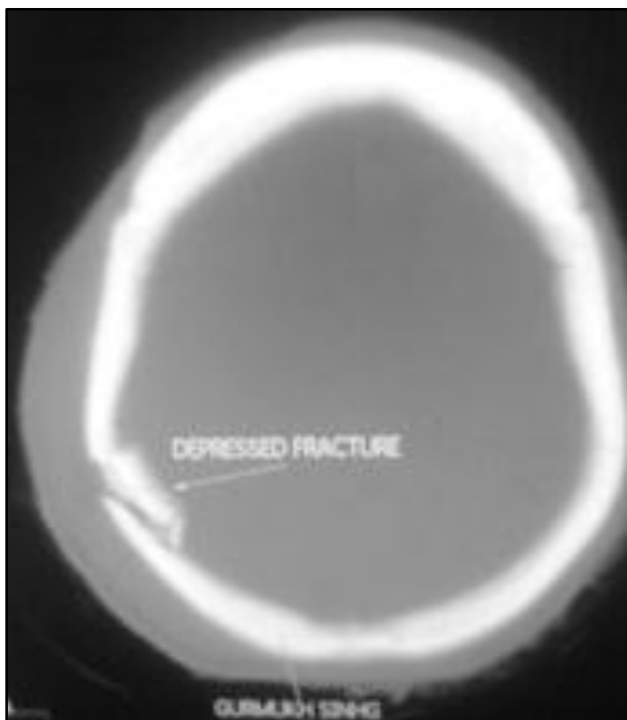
CT Axial and 3D Reformatted Image showing Fractures
